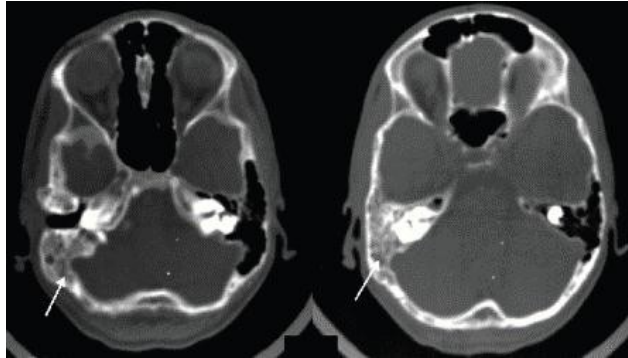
Acute mastoiditis shown on CT and clinically
